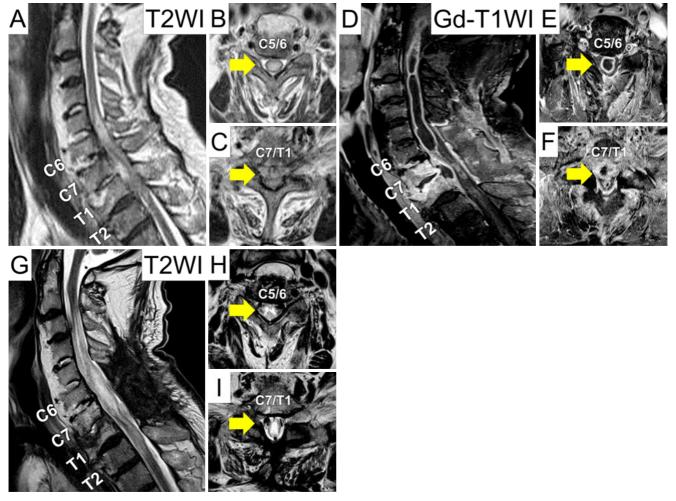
Preoperative, postoperative, and final follow-up magnetic resonance imaging (MRI).
